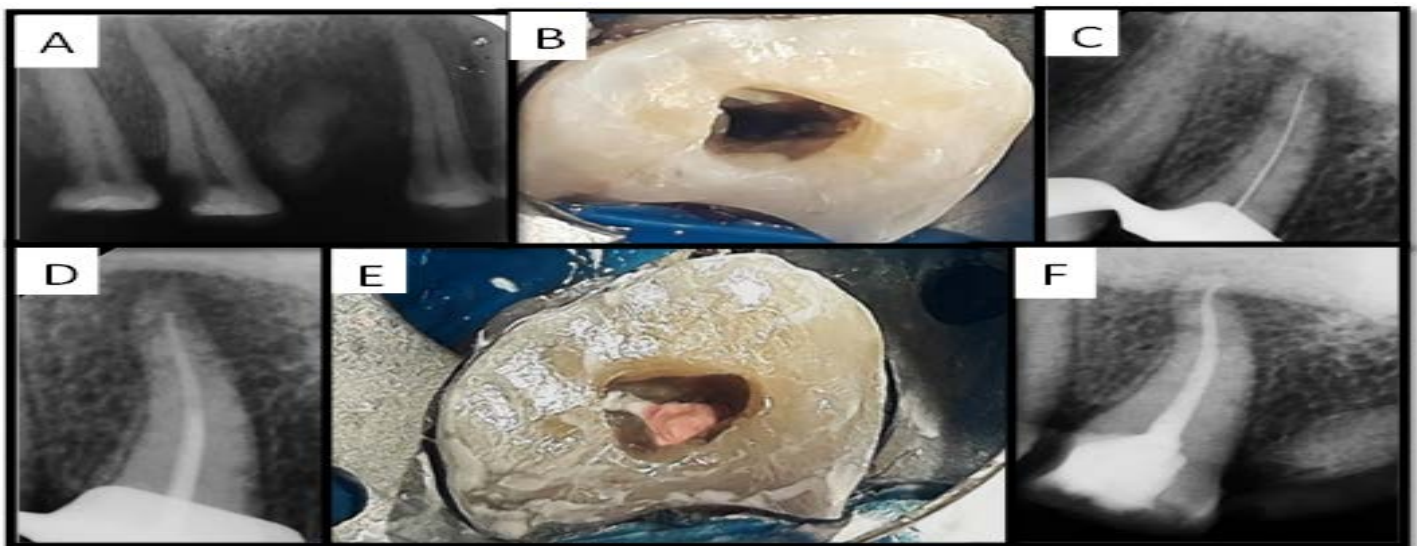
A) Preoperative Radiograph. B) Access Cavity Preparation. C) Working Length Radiograph. D) Master Cone Radiograph. E&F) Clinical & Radiographical picture After Obturation.
